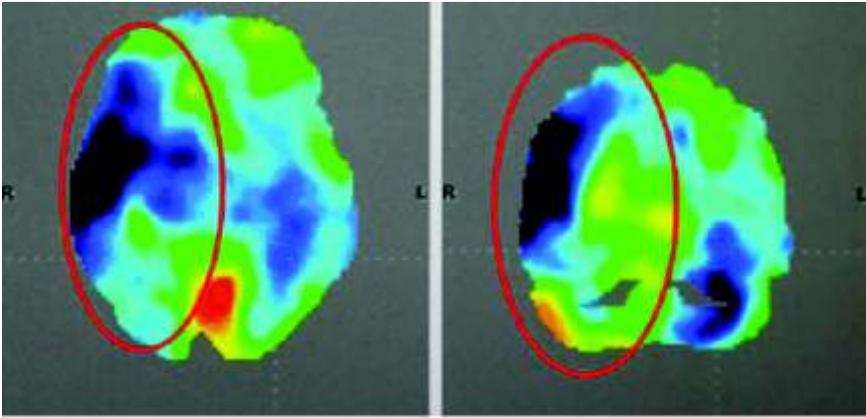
PET-CT scan 1 year after Autologous BMMNCs transplantation showing improved metabolism in the parietal lobe penumbral regions seen as reduction in the blue coloured areas
